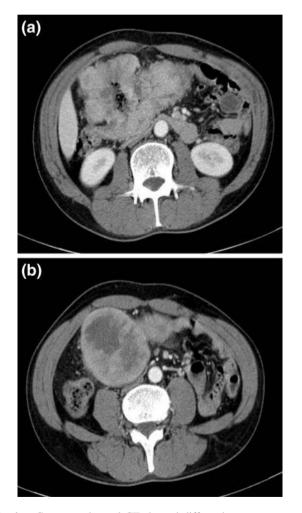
a Contrast-enhanced CT showed diffuse, homogeneous, and lobulated wall thickening of the right transverse colon. b Contrast-enhanced CT caudad to \mathbf{a} showed a solid mass with a central low-density area suggesting necrosis
